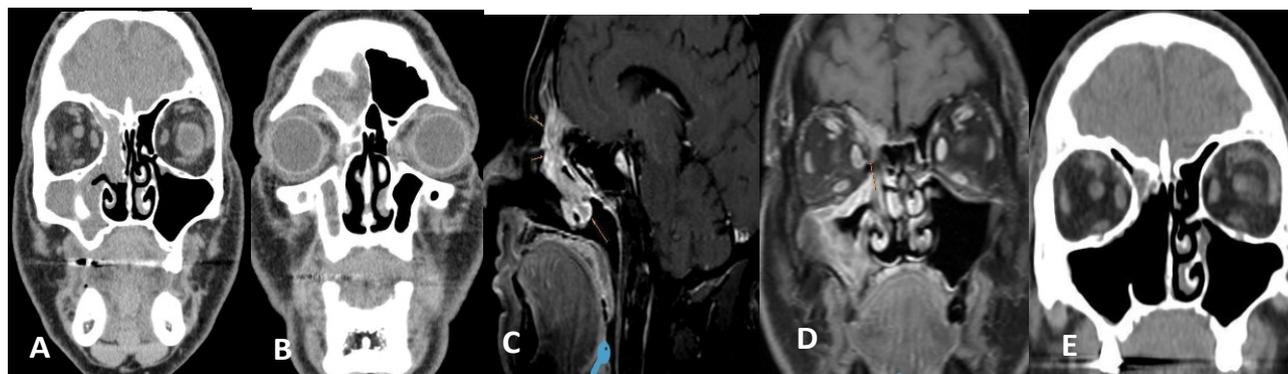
Metachronous squamous cell carcinoma with IP (T2N0M0) (A, B) CT: Rightmaxillo-ethmoid-frontal occupation is observed; (C, D) MRI showing ethmoid and frontal recess involvement; (E) Postoperative CT (medial maxillectomy, ethmoidectomy, DRAF II-B).
